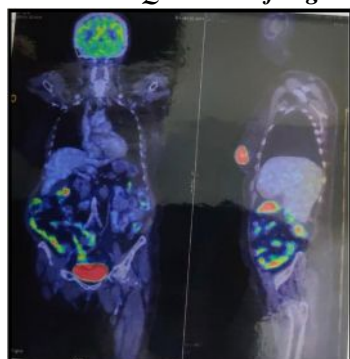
PET CT Showing Irregular lobulated Solid Lesion in Right Breast with no other Metabolically Active Lesion in Body
